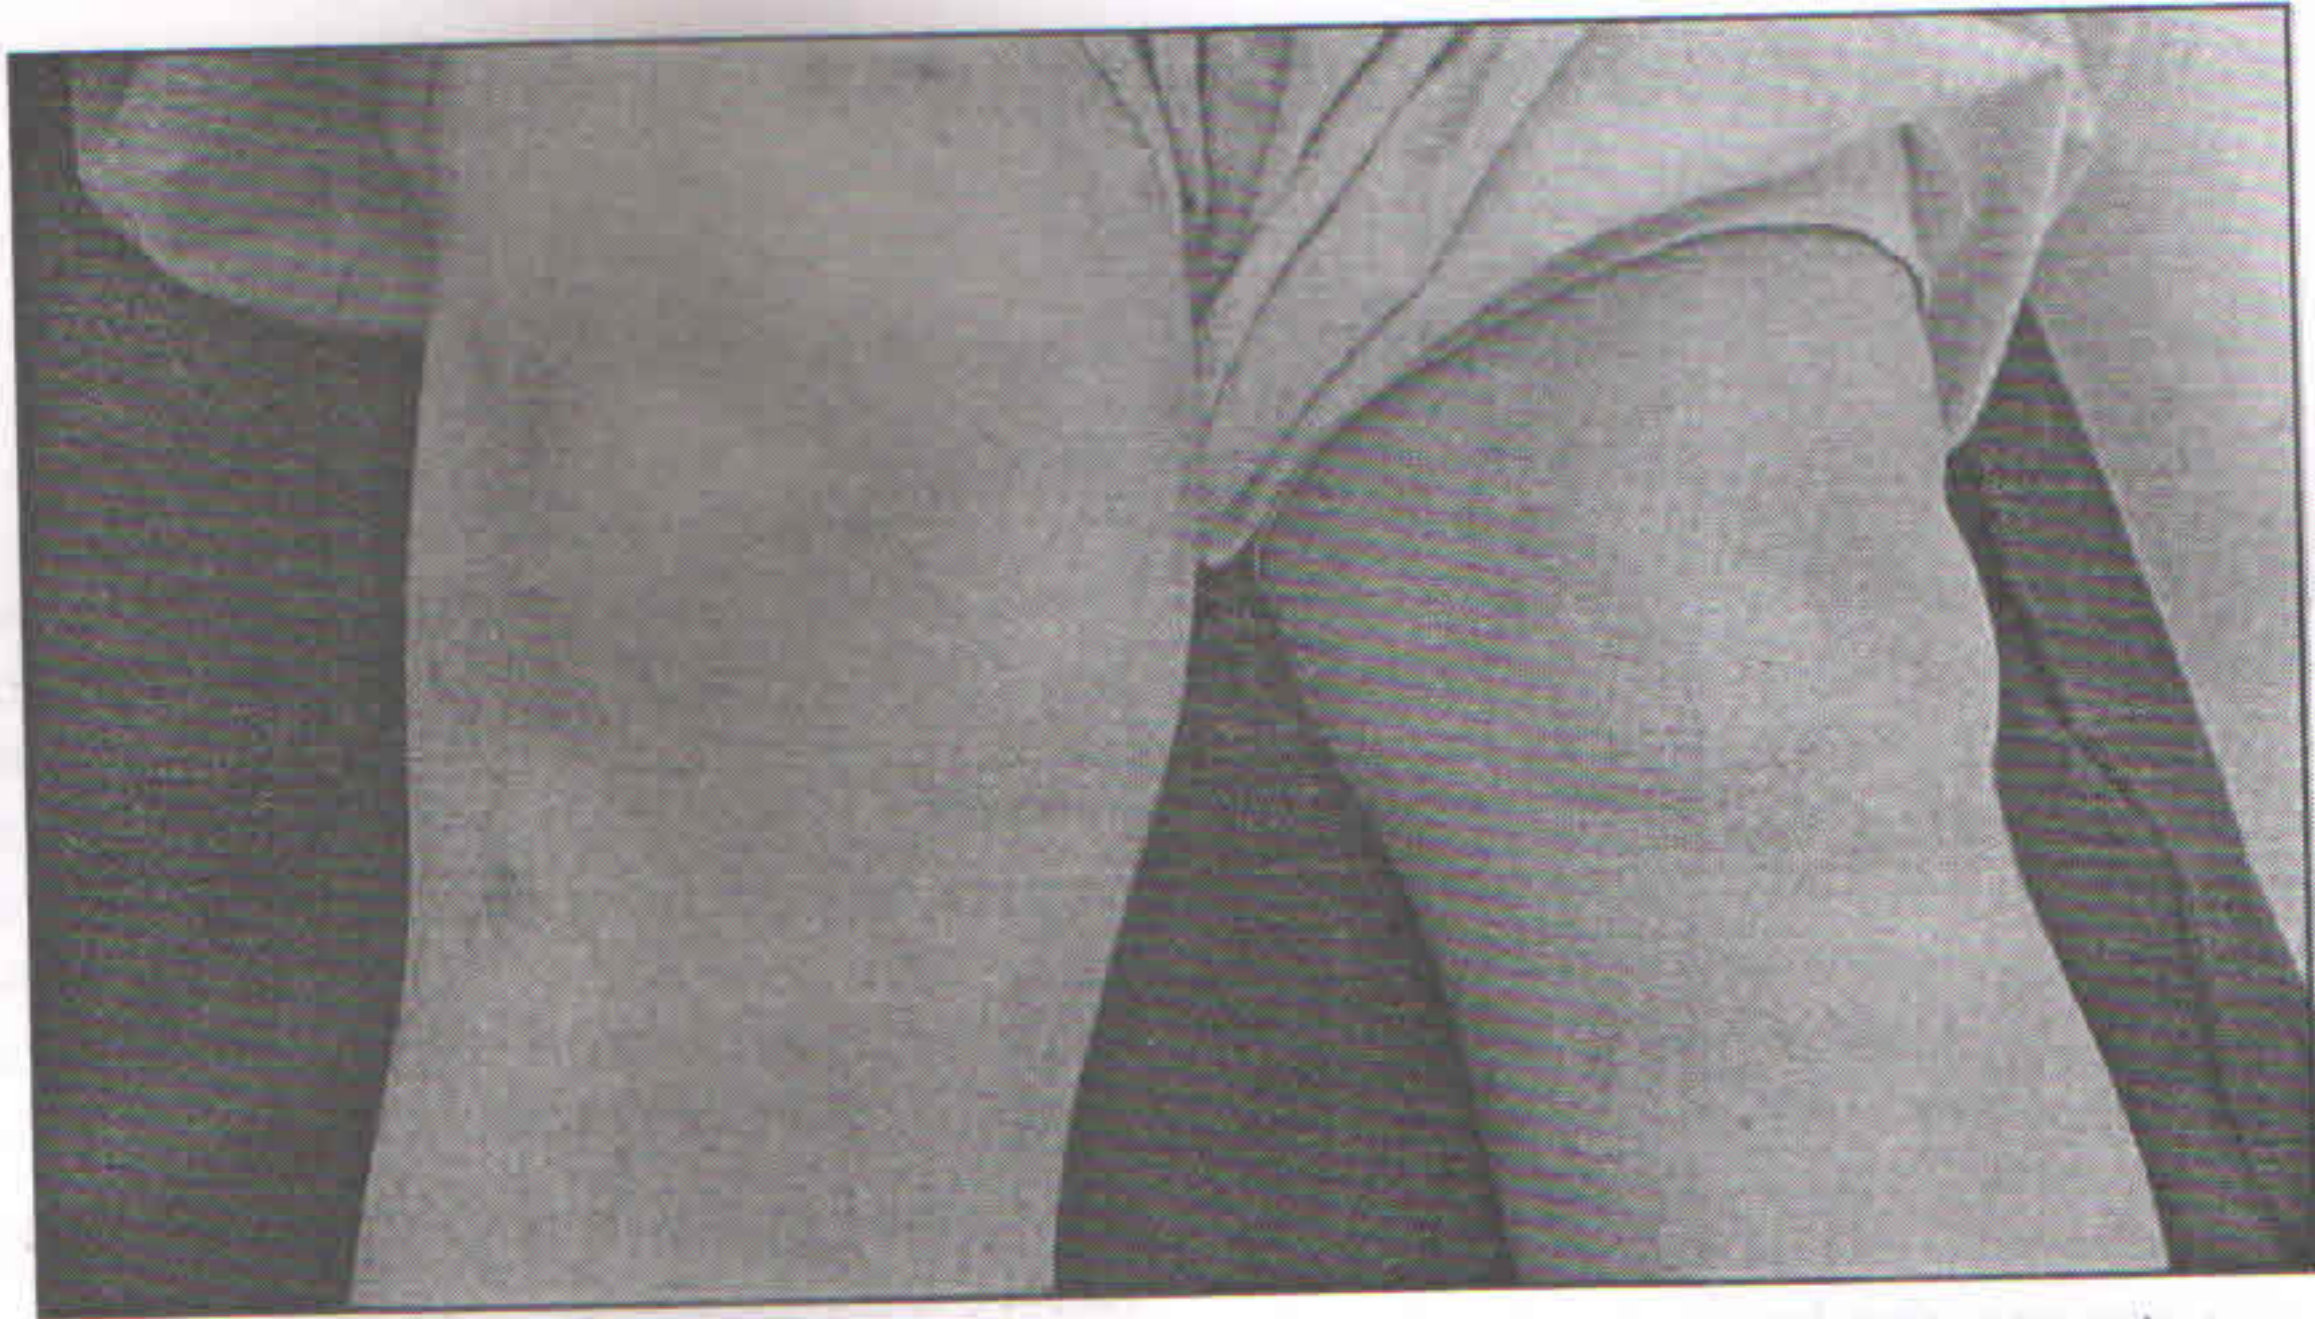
53 year old lady with pain on medial femoral condyle. Her Xray was normal
